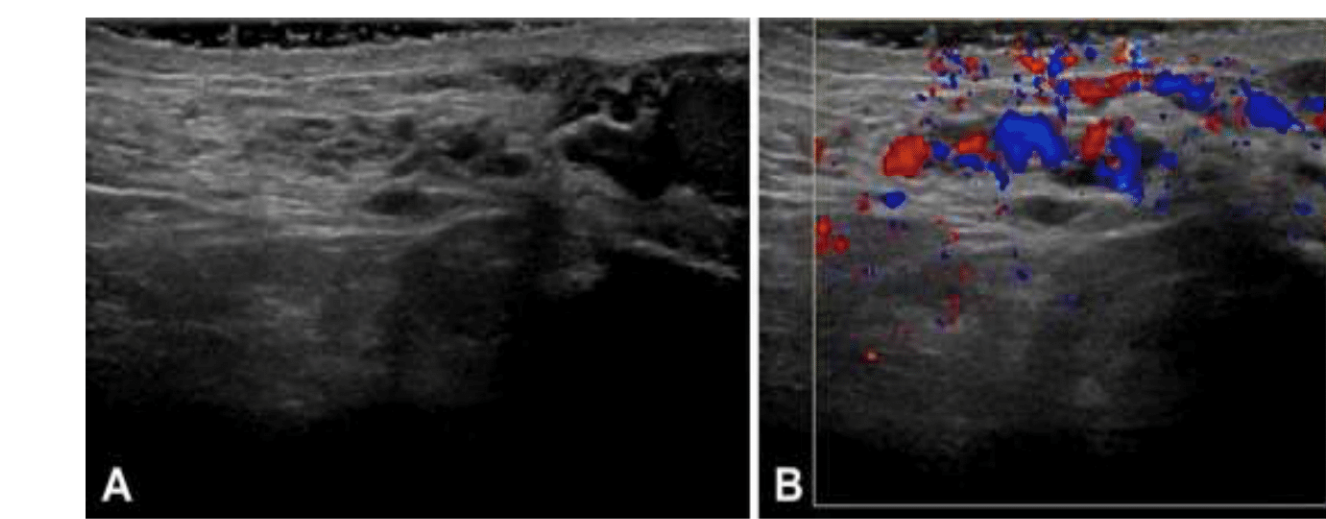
Example Sarteschi Grade 1 Varicocele (reflux in the vessels of the inguinal canal seen only during the Valsalva manoeuvre without any visible reflux during standard ultrasound examination).⁵
